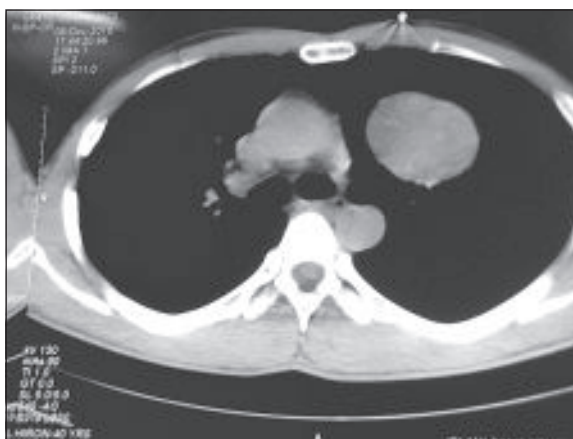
CT scan of the chest showing a growth in the left mediastinum.
